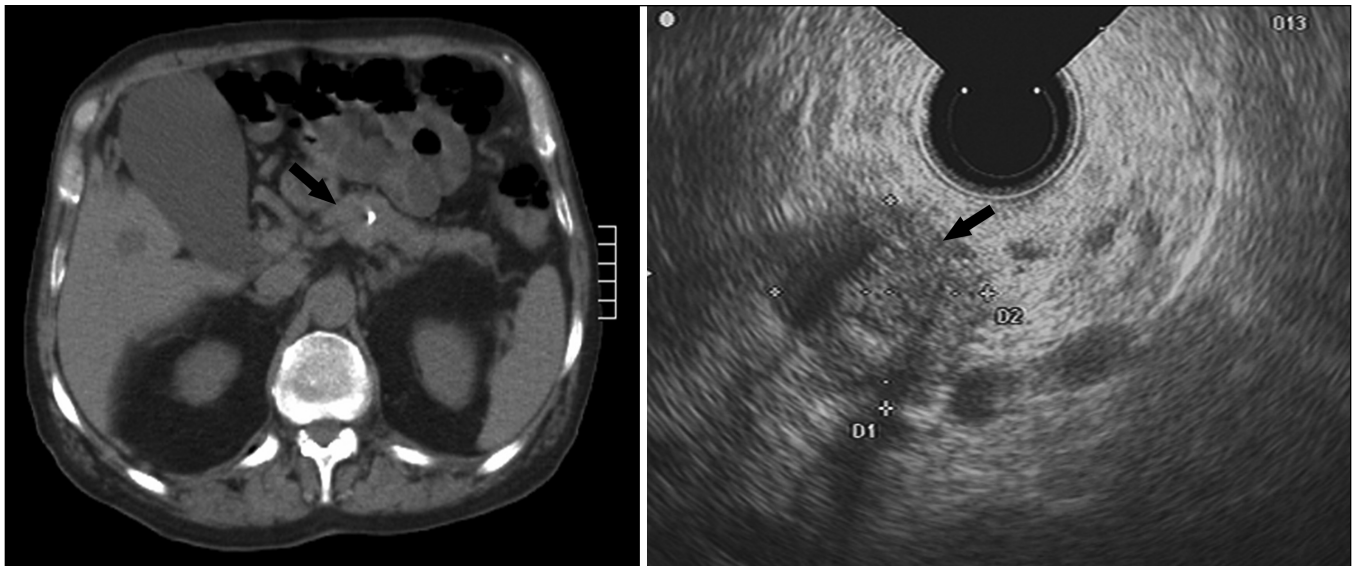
Left panel Computed tomography image showing a ‘calcified’ focus within the body of a pancreas, but no definite mass was reported (arrow). Right panel Endosonographic image showing a discrete hypoechoic mass (arrow) within the body of a pancreas. Endoscopic ultrasound-guided fine needle aspiration from a mass reported as a neuroendocrine tumour
